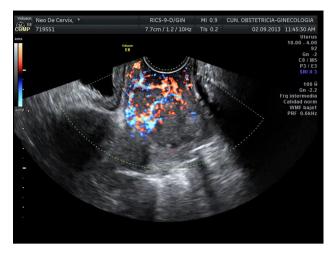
Transvaginal color Doppler from a cervical cancer showing an abundant vascularization
